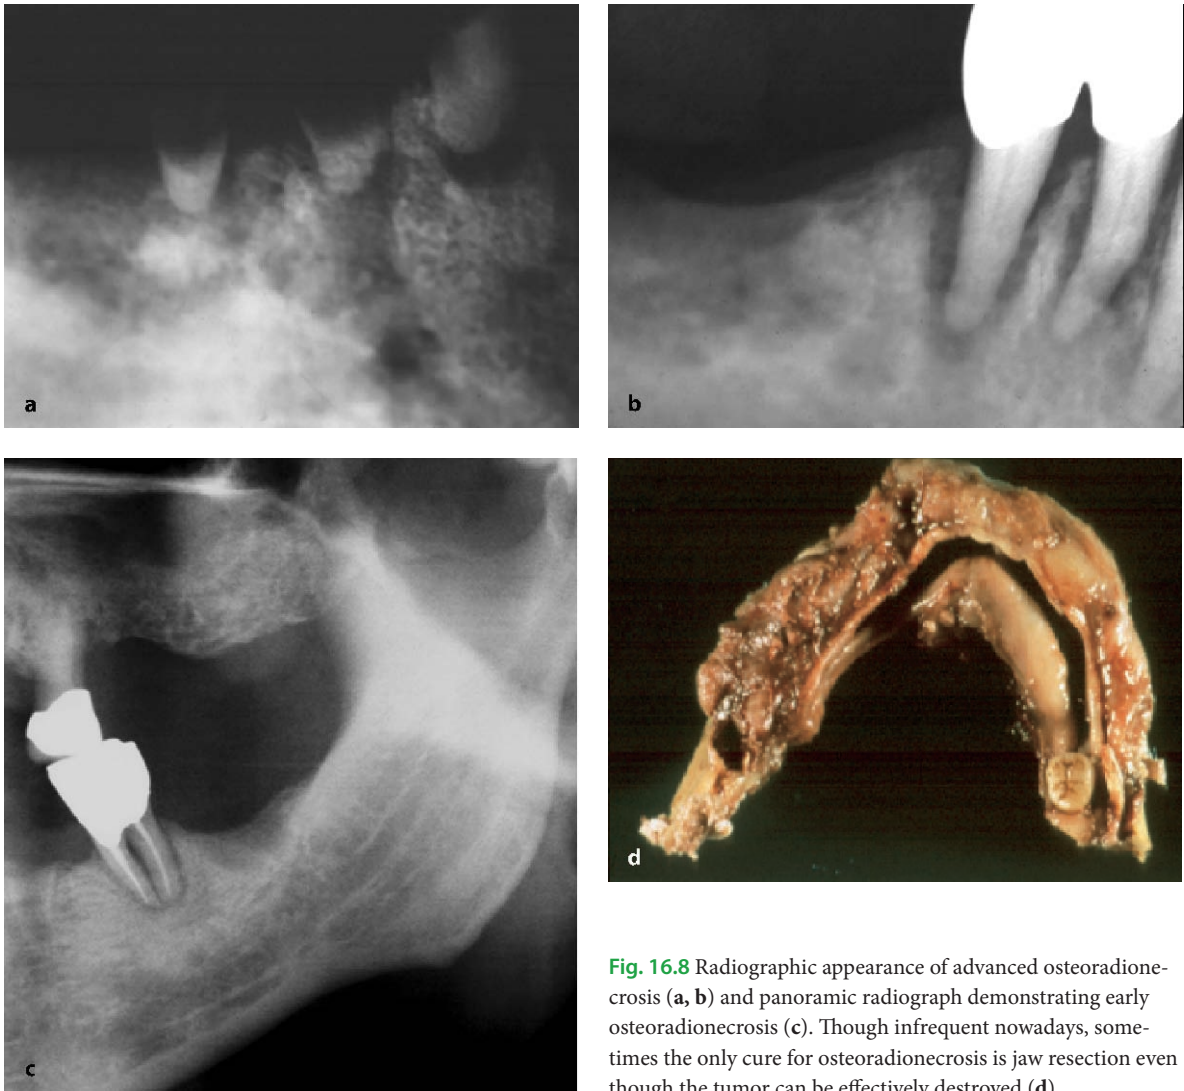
Radiographic appearance of advanced osteoradionecrosis (a, b) and panoramic radiograph demonstrating early osteoradionecrosis (c). Though infrequent nowadays, sometimes the only cure for osteoradionecrosis is jaw resection even though the tumor can be effectively destroyed (d)
